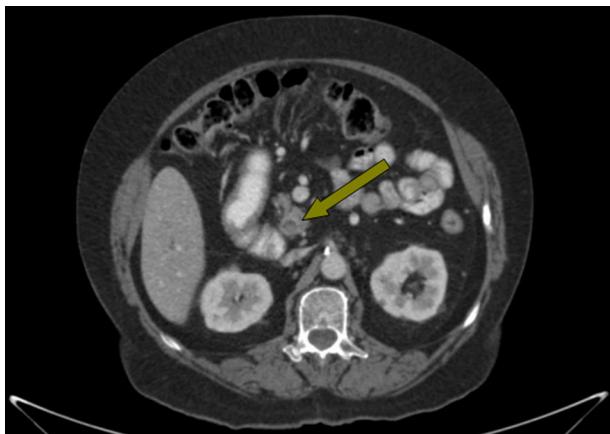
Distal choledocholithiasis. Abdominal CT scan, where gallstones are observed in the distal end of the bile duct, which conditions the retrograde dilatation of the extrahepatic duct, without identifying abnormalities in the pancreatic cephalic portion.
